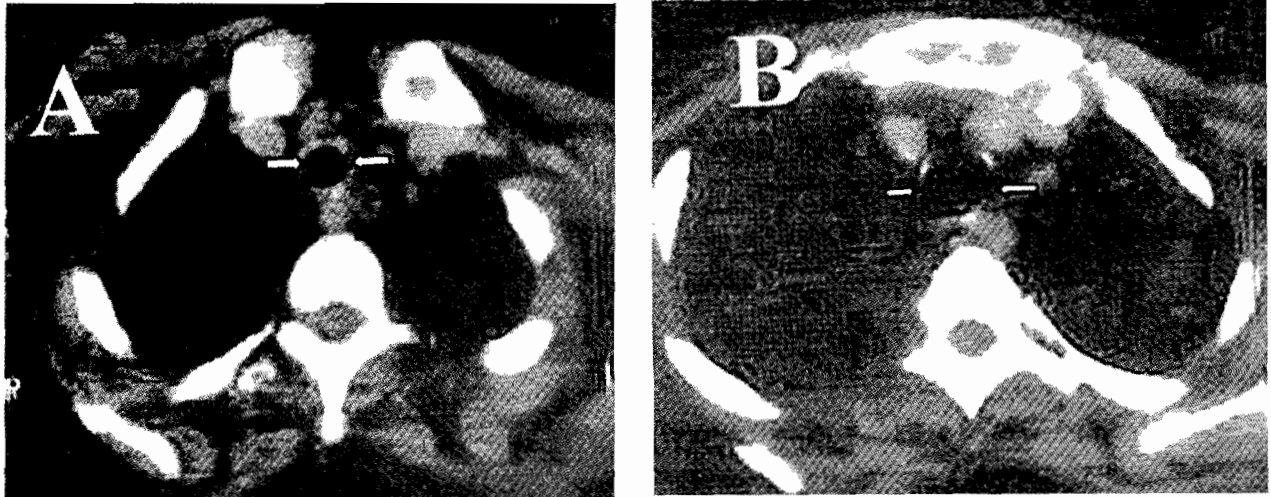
A. Plain CT scan of the neck in a 14-year old female with acquired tracheal stenosis (white arrows) (Case # 2). B. Plain CT scan of the same patient after 7 months of repeated rigid bronchoscopic dilatation of the trachea. The tracheal size is normal (White arrows).
